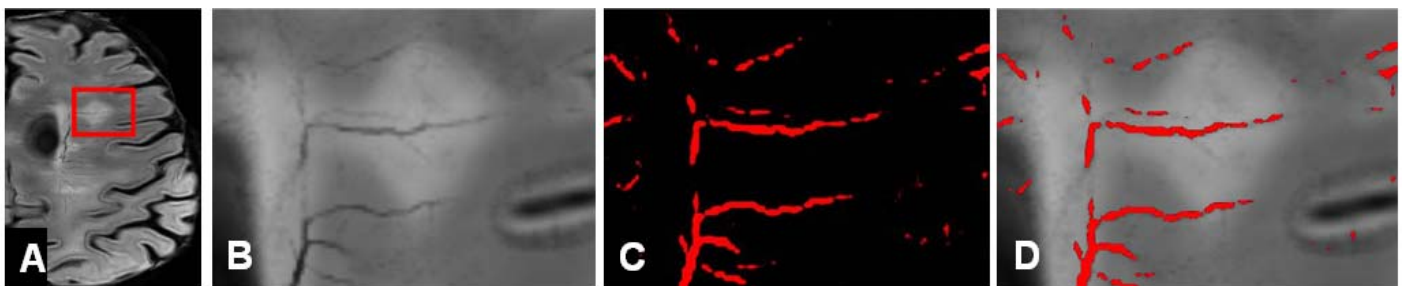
Venous vessel centered MS lesion: (A) FLAIR-SWI, (B) represents the subsection of the area marked with the red rectangle in (A). The automatically segmented veins are shown in (C) and (D) shows the MS lesion overlaid with the segmented vessels.
